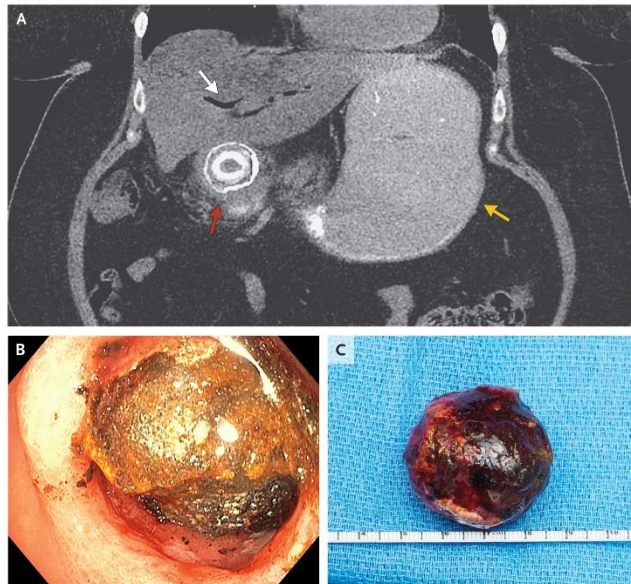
CT finding of a cholecysto-gastric fistula with a large stone.
